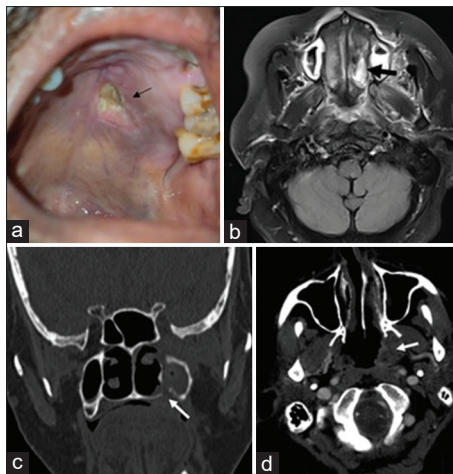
Mucormycosis with oral and palatal involvement. (a) Photograph image shows erosion of palate (black arrow), (b) Axial fat suppressed T2 weighted image shows left palatal involvement (white arrow) with inflammation in left masticator space, (c) Coronal CT image (bone window) shows erosion of medial and inferior wall of left maxillary sinus with oroantral fistula (white arrow), (d) Axial post contrast CT images shows peripherally enhancing soft tissue lesion in fossa of Rosenmuller (white arrow). CT: Computed tomography
